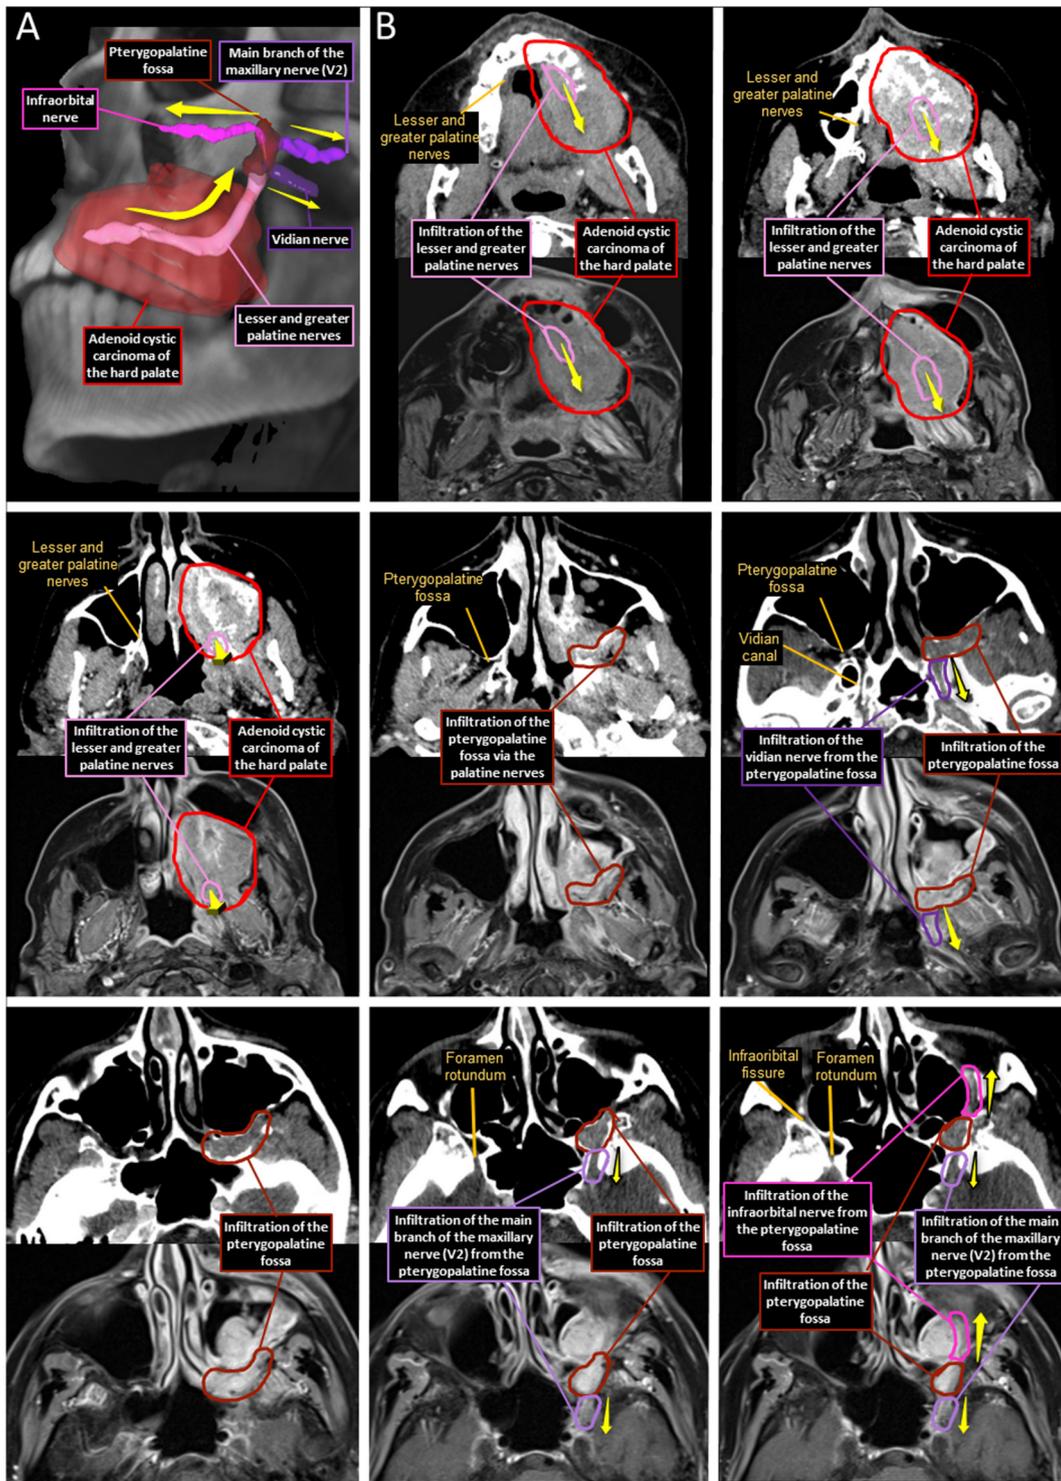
Adenoid cystic carcinoma of the hard palate with macroscopic PNI of branches of the maxillary nerve (V2). (A) 3D overview of the extension pathways (yellow arrows) along the lesser and greater palatine nerves, infiltrating in a retrograde manner the pterygopalatine fossa and then infiltrating the Vidian nerve (in the Vidian canal) and the main branch of the maxillary nerve (through the foramen rotundum) and in an anterograde manner the infraorbital nerve (through the infraorbital fissure). (B) Axial views of both CT-scan and corresponding post Gado T1-weighted MRI of the different nerve extension pathways from the bottom-up. Abbreviations. PNI: perineural invasion; CT: computed tomography; Gado: gadolinium; MRI (magnetic resonance imaging).
